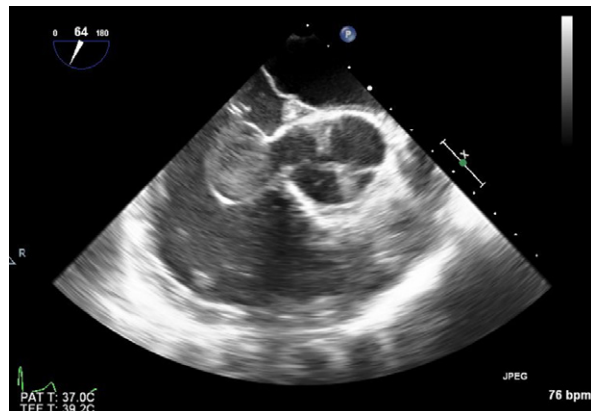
Transesophageal echocardiogram shows the aneurysm of the noncoronary sinus of Valsalva.
